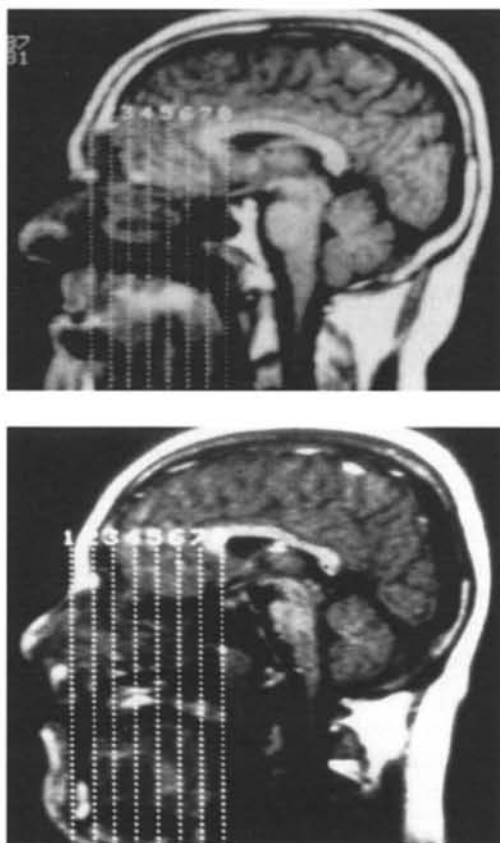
Mid-sagittal MRI showing the differences in presentation and anatomic detail between T_1 (10a) and T_2 (10b) weighted images. Numbers indicate position of 2D reformatted coronal views.
